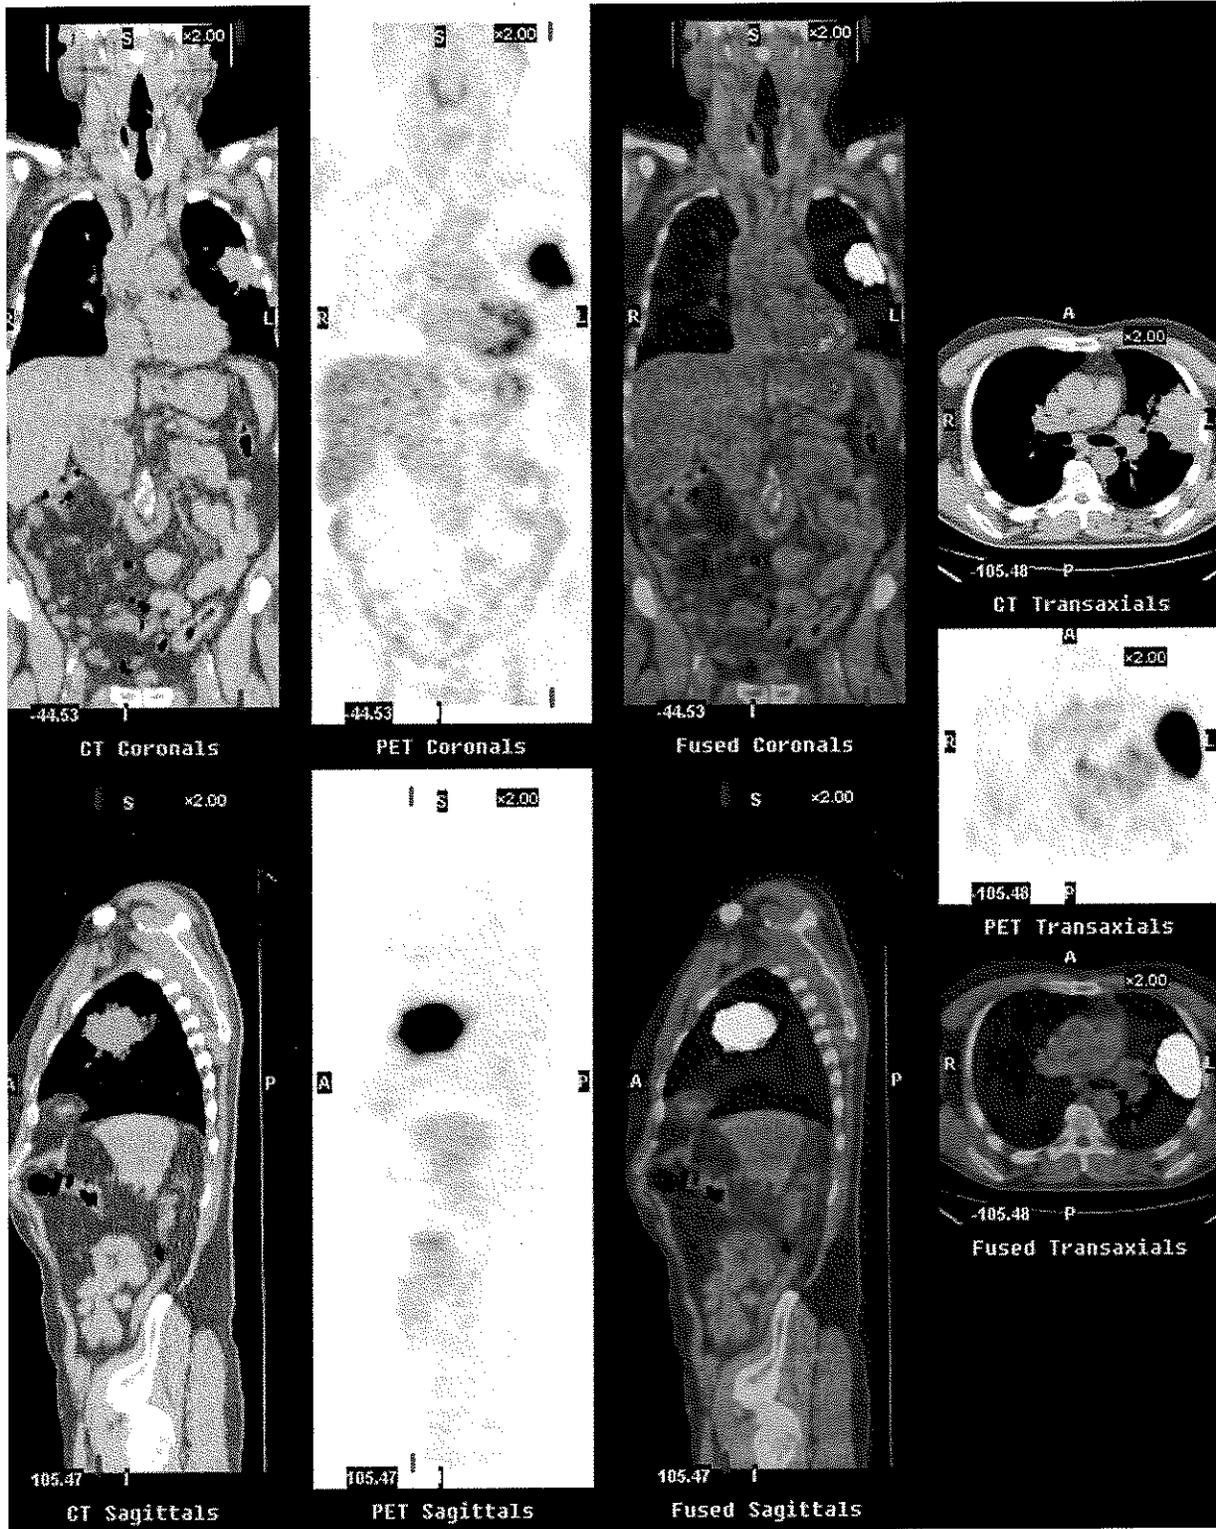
Fusion of positron emission tomography (PET) and CT images from a CT/PET scanner to localize a left lung tumour.
